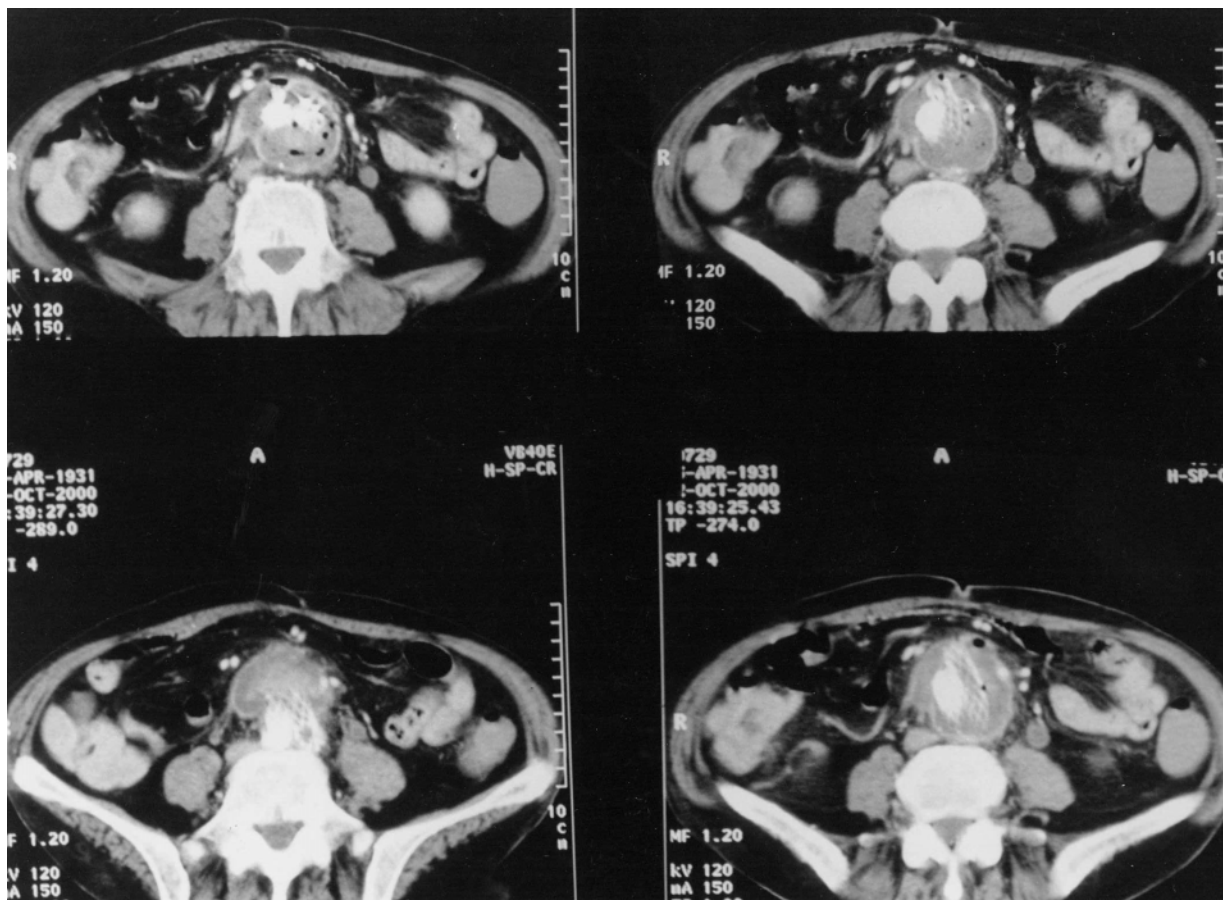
Spiral CT scan (22 months after implantation) shows displacement of the occluded left branch against the first jejunal segment with air bubbles inside the thrombus and enlargement of the aneurysm itself.
